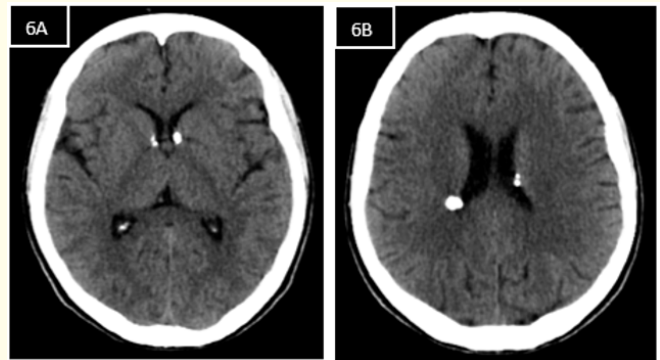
Findings of tuberous sclerosis in brain CT. A) and B) at the level of the subependymal space, multiple irregulars, hyperdense images are visualized, with attenuation coefficients of up to +898 HU, the largest of them at the level of the body of the right lateral ventricle, measuring 0.8 x 0.6 cm, findings in relation to subependymal hamartomas.
